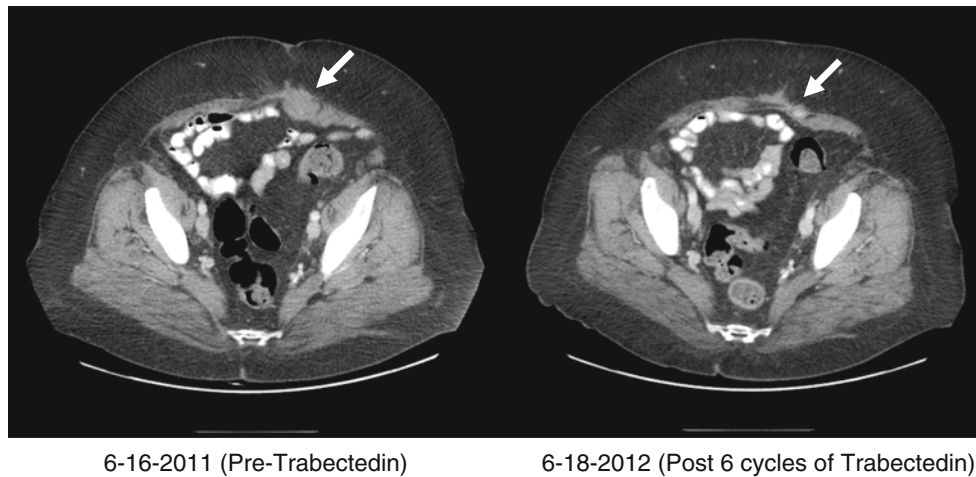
CT scan images showing a response in a patient with recurrent adenosarcoma (baseline and post 6 cycles of trabectedin)
